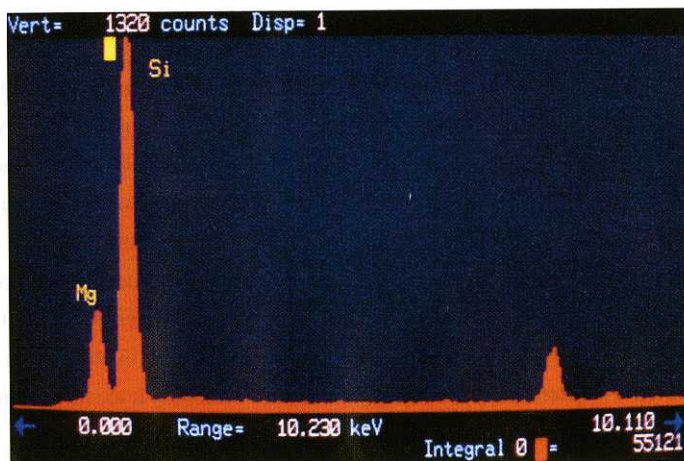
Elemental composition of healthy human hilar lymphnodes using X-ray microanalysis of epoxy section. (by courtesy of Prof. K. Sasaki and chief technician of our EM research center; Mr. K. Uehira).
